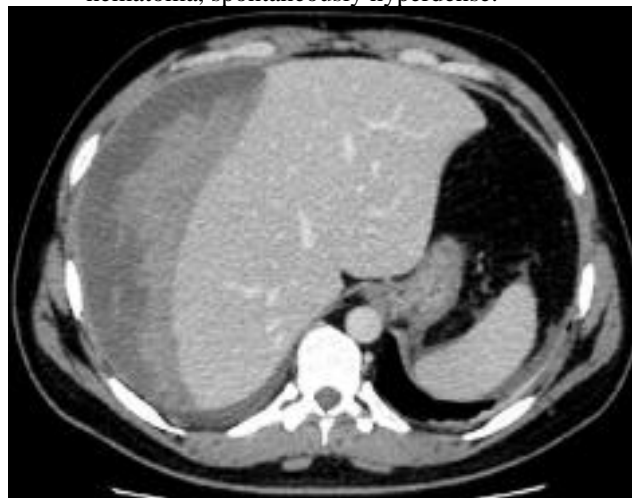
Abdominal CT scan, post-contrast phase, coronal plane: large hepatic subcapsular hematoma, free intraperitoneal fluid.
